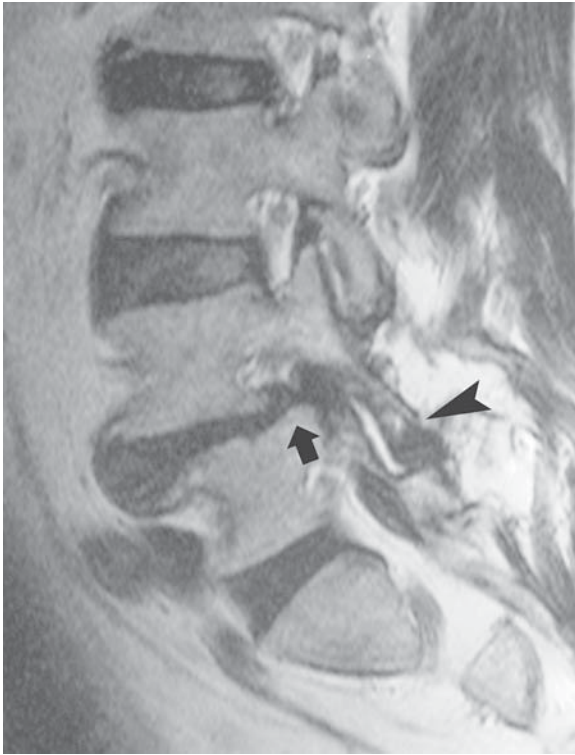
Degenerative spondylolisthesis. Sagittal T2-weighted image shows degenerative anterior spondylolisthesis of L4 on L5 (arrow) with related degenerative changes and fluid in the facets (arrowhead).
